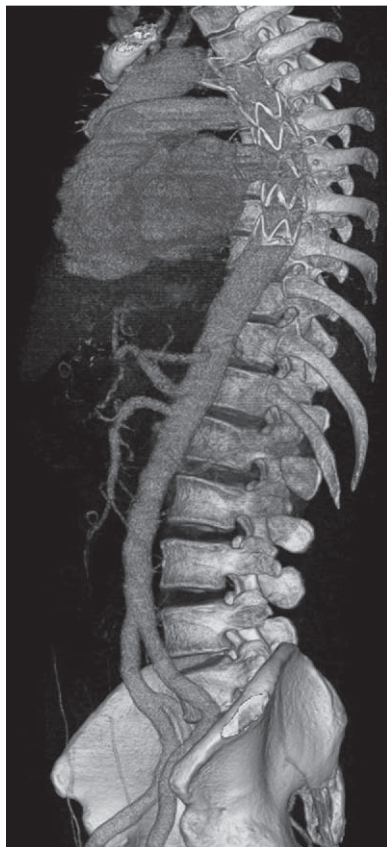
Complete aortic remodeling in acute type I aortic dissection (AD) is shown in a computed tomography angiography 6 months after extended thoracic aortic repair for acute AD. The false lumen is completely obliterated along the entire aorta.
